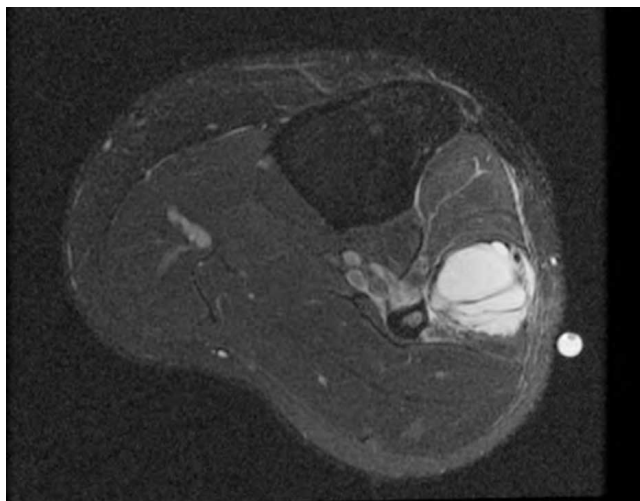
Ruptured peroneal ganglion cyst. T2 fat-saturated axial MRI shows a multiloculated cyst within the extensor digitorum longus muscle.
